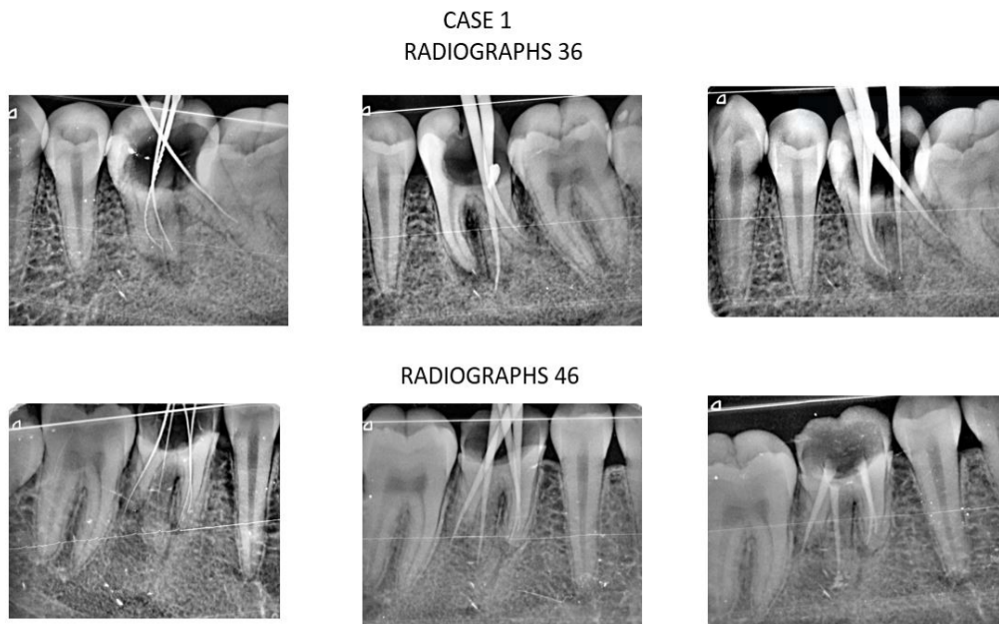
(A) Radiographs of case 1 - tooth number 36 (B) Radiographs of case 2 - tooth number 46
